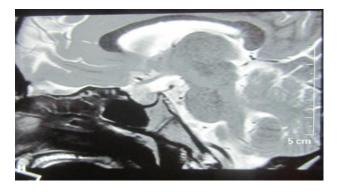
MRI brain showing enlarged pituitary gland.
